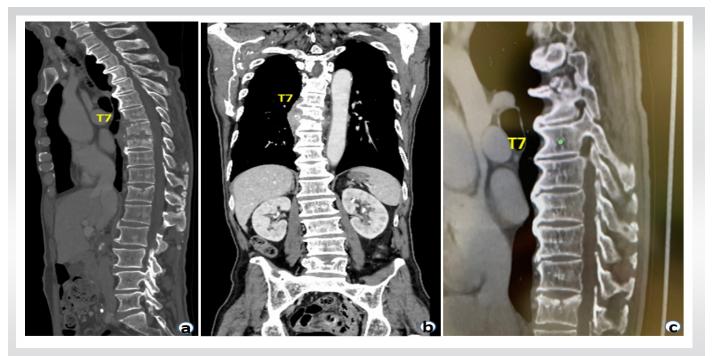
(a) Sagittal image of a plain computed tomography (CT) scan showing destruction of the T7, T8, and T9 vertebrae and ankylosis of the spine from T2 to T7 with ossification of the anterior longitudinal ligament (ALL). (b) Coronal image of a contrast-enhanced CT scan showing paravertebral soft-tissue swelling at the T7, T8, and T9 vertebrae with vertebral destruction and ankylosis of the spine from T9 to L1. (c) Sagittal CT image taken 1 year before the referral demonstrating the presence of ankylosis with ossification of the ALL in the thoracic spine including the T7, T8, and T9 vertebrae.
